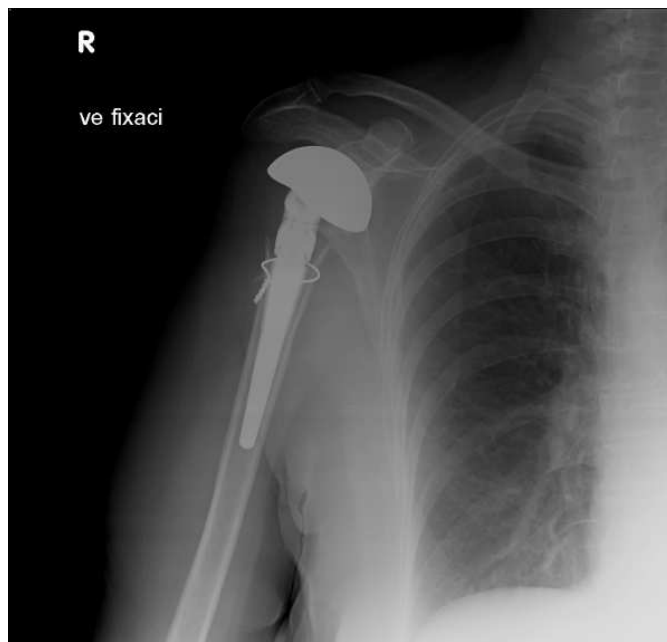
X-ray image of the patient's surgically repaired shoulder via reverse shoulder endoprosthesis
